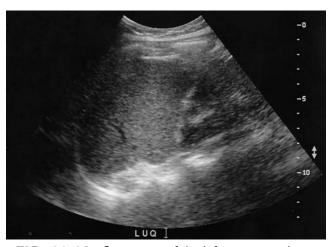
Sonogram of the left upper quadrant.
